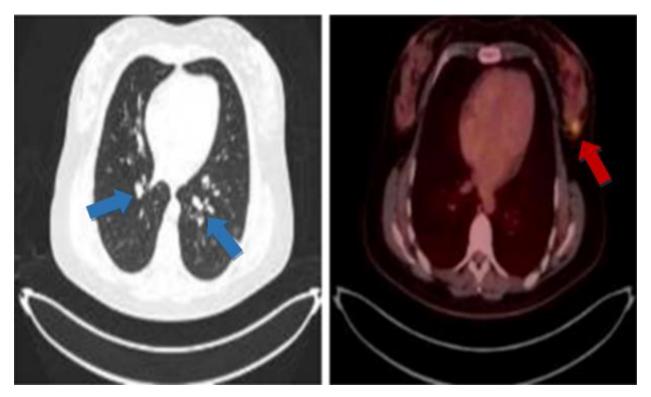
PET CT showed, in red arrow, a hypermetabolic nodular lesion in the union of lateral quadrants of the left breast, associated with hypermetabolism in small bilateral pulmonary nodules and in secondary hilar lymph nodes in blue arrow.
